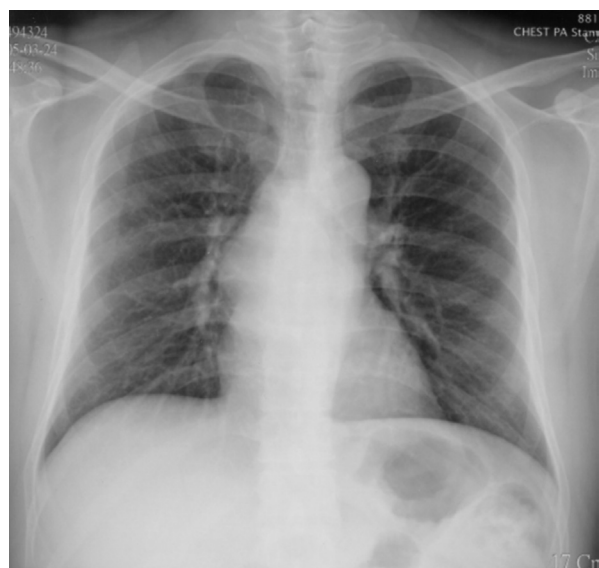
Chest X-ray showing a middle mediastinal mass.
